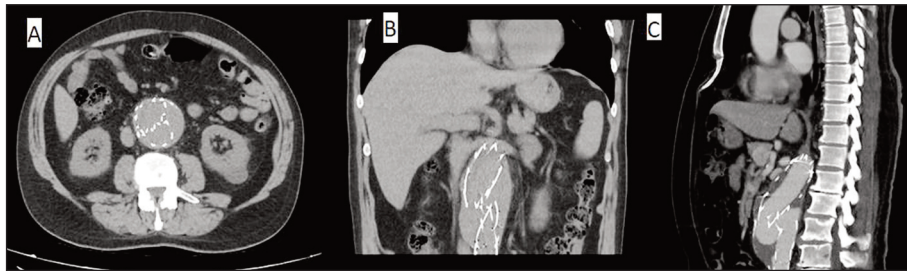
Computed tomography images of Type III endoleak and abdominal aortic aneurysm. A: Axial; B: Coronal; C: Sagittal images.
